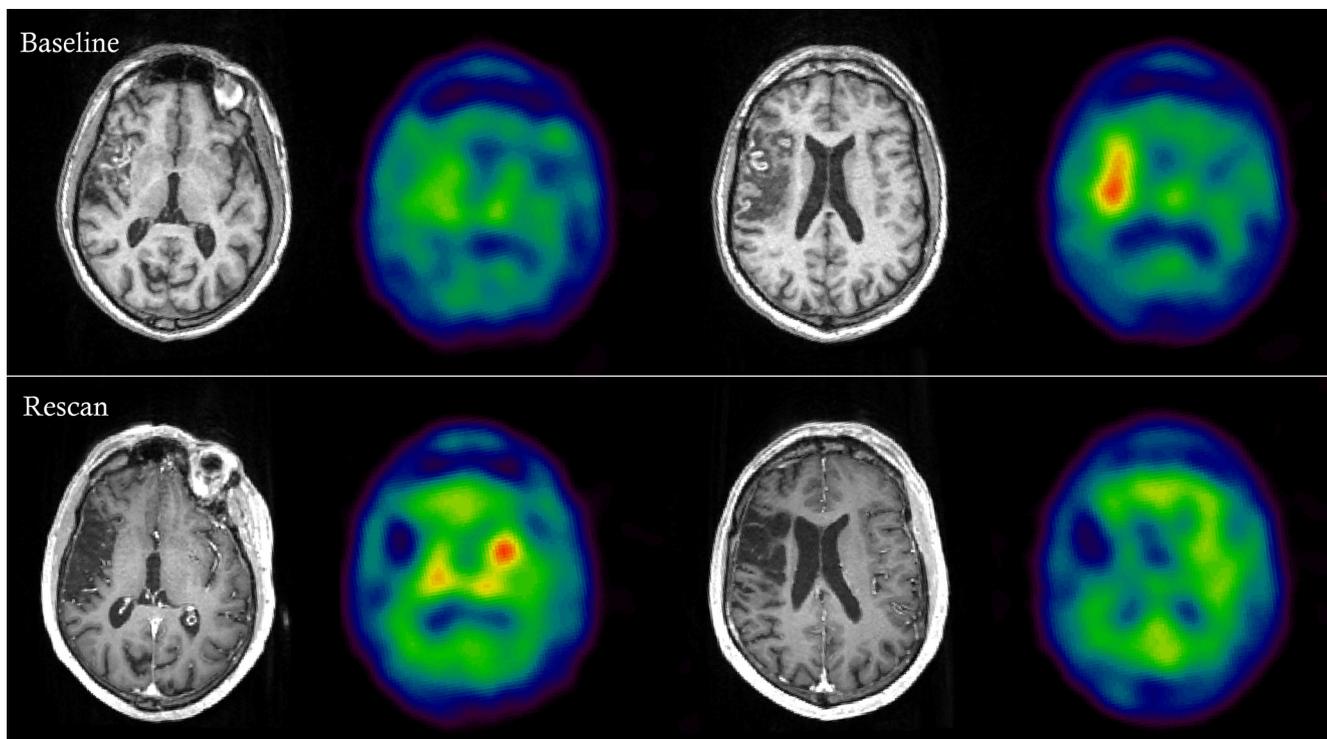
65 years old male with an acute onset of severe left-side hemi-paresis. The initial scan revealed a large infarct in the supply-area of the right middle cerebral artery. The patient was scanned with (panels 2 and 4 from the left) [¹²³I]CLINDE-SPECT and (panels 1 and 3) T1-MRI at baseline four weeks after onset (upper row) and rescanned again after another 7 months (lower row). At baseline the patient was still emitted at a hospital rehabilitation unit and presented clinically with fine motor disability of the left upper extremity. The baseline SPECT scan displays an increased binding of CLINDE to TSPO relating to the peri-infarct area. At rescan, clinically, the patient was well recovered and had only very discrete fine motor impairment of the left hand despite of the large loss of tissue displayed on the T1-MRI. The CLINDE binding to TSPO with regards to the peri-infarct area has decreased, however, binding of CLINDE to TSPO has increased in the insular area of the contra-lesional hemisphere. Increased contra-lesional TSPO binding could represent the role of activated microglia in neuromodulation and rehabilitation. Courtesy of Per Jensen, NRU.
